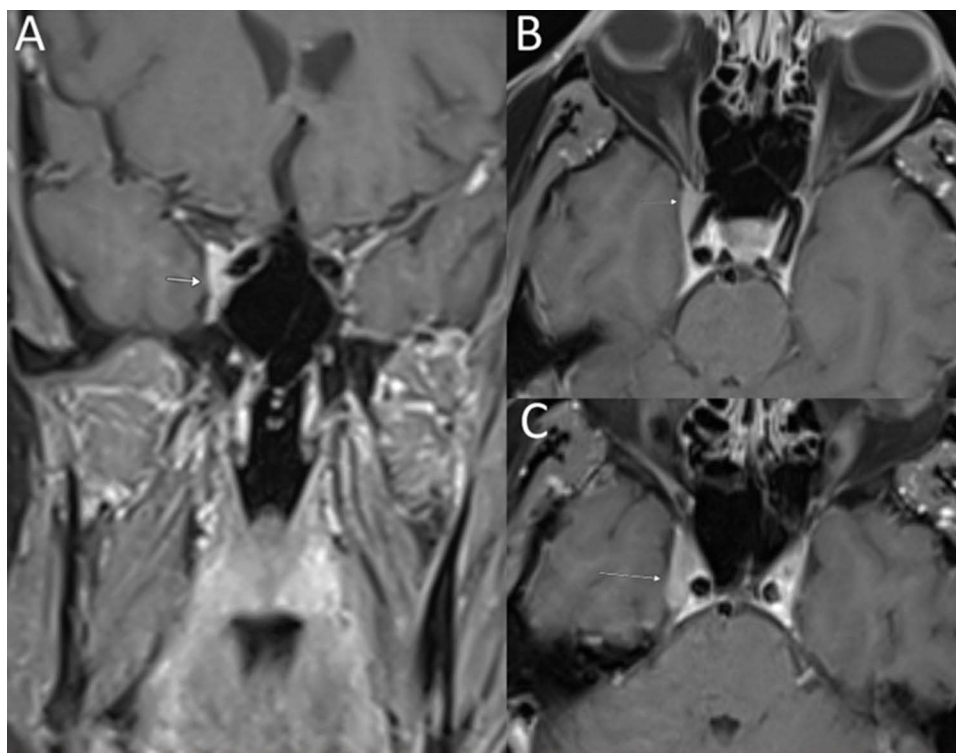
57-year-old man with multiple cranial neuropathies. Coronal (A) and axial (B and C) contrast-enhanced T1-weighted MR images showing a nodular enhancing lesion within the anterior right cavernous sinus (arrows) (B-cell lymphoma on biopsy).
